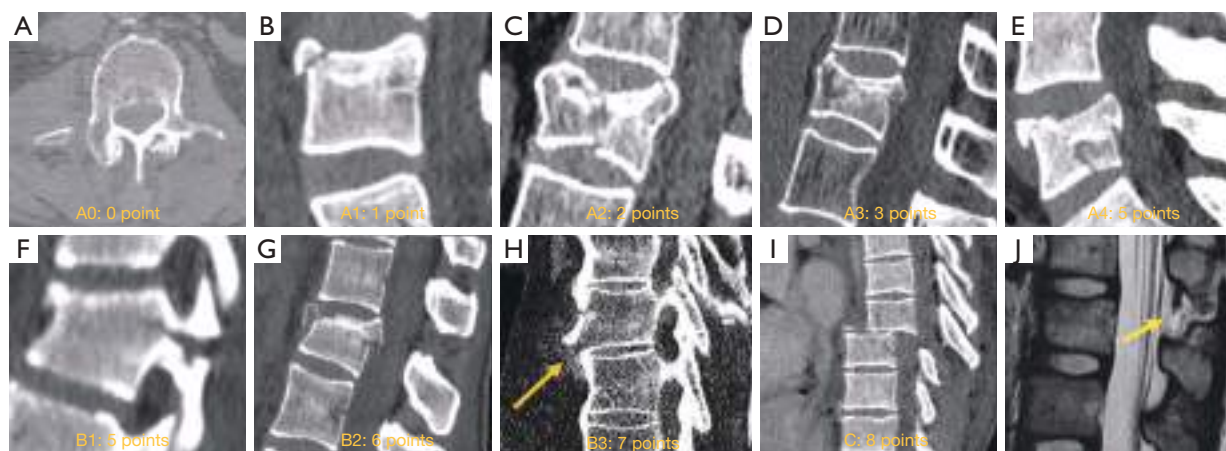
AO-Spine thoracolumbar fracture classification score. (A) A0. Apophyseal fracture. (B) A1. Compression fracture without involvement of the posterior wall. (C) A2. Split fracture without involvement of the posterior wall. (D) A3. Burst fracture with involvement of one endplate. (E) A4. Burst fracture with involvement of both endplates. (F) B1. Trans osseous fracture. (G) B2. Posterior tension band injury fracture. (H) B3. Anterior tension band injury fracture (arrow). (I) Fracture dislocation injury type C. (J) MRI showing flavum (arrow), interspinous and supraspinous ligamentum tear. AO, Arbeitsgemeinschaft für Osteosynthesefragen; MRI, magnetic resonance imaging.
